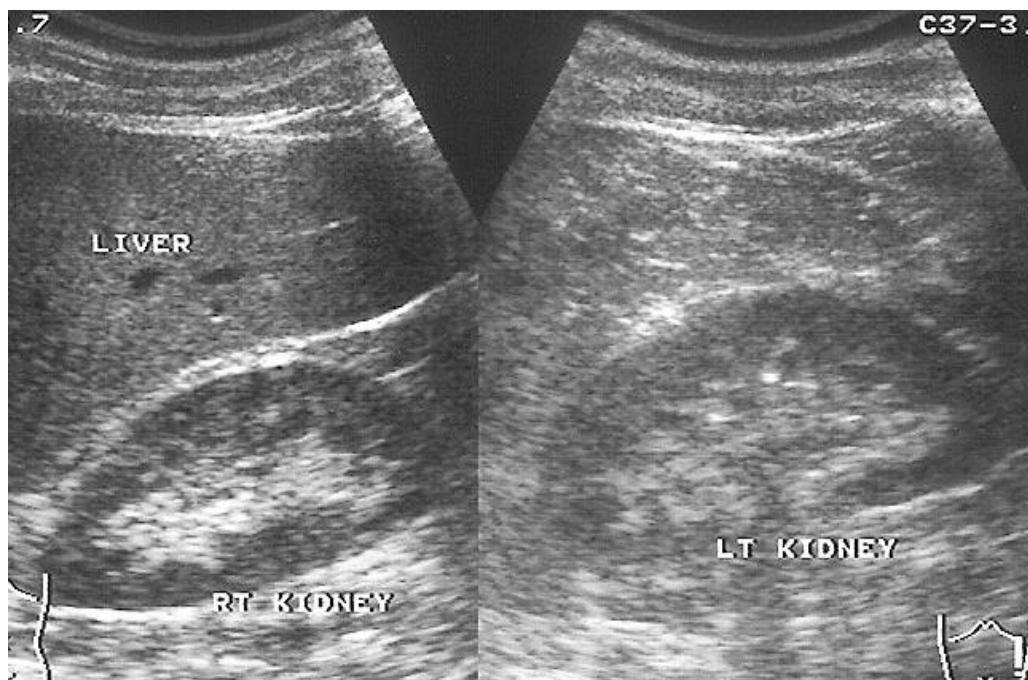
Sonogram of normal left and right kidneys. Note the dark cortex and the echogenic (white) medulla due to the connective tissue (collagens) in the pelvi-calyceal system.
